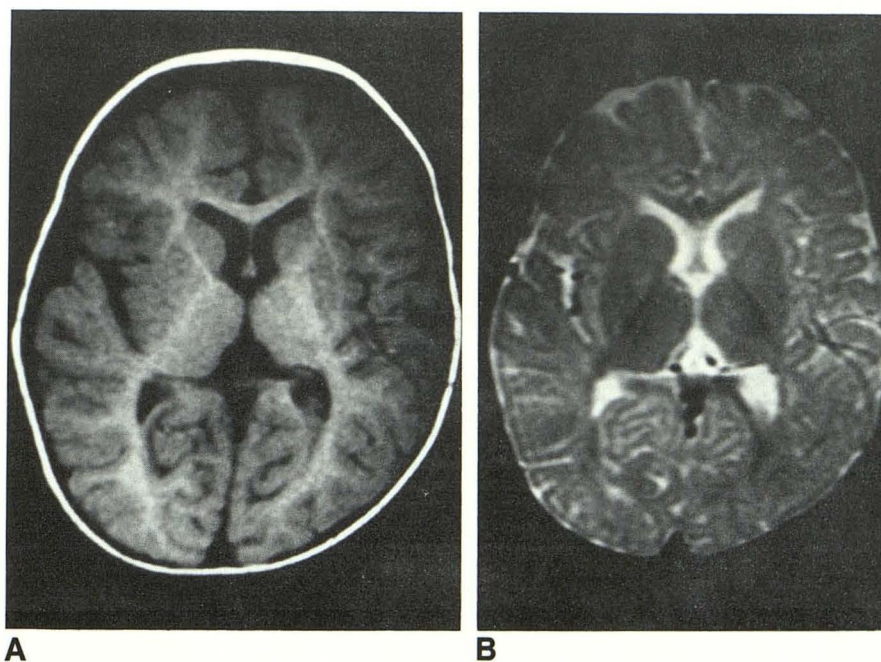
A and B, 10-month-old child. Axial T1-weighted, 600/20 (A) and T2-weighted, 2500/80 (B) images. Anterior limb of internal capsule and genu of corpus callosum have a degree of myelination comparable to the posterior limb of the internal capsule on T1- and T2-weighted images.
